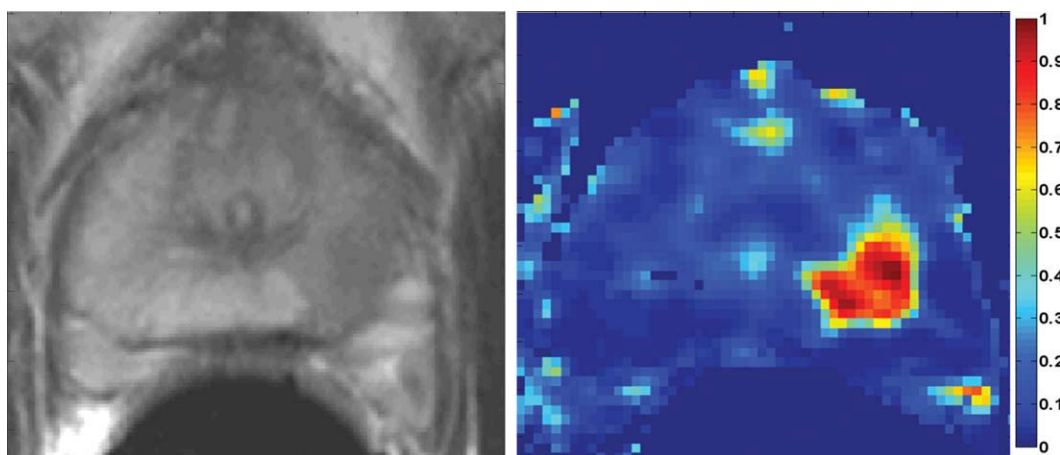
Left: T2-weighted MRI of the mid-gland of a patient with biopsy confirmed cancer in mid-left region. Right: The SVM-based cancer probability map, with hot colors showing higher P_c . The Gleason score: 4 + 5, the average P_c in the tumor area: 0.9. [Color figure can be viewed in the online issue, which is available at wileyonlinelibrary.com.]
